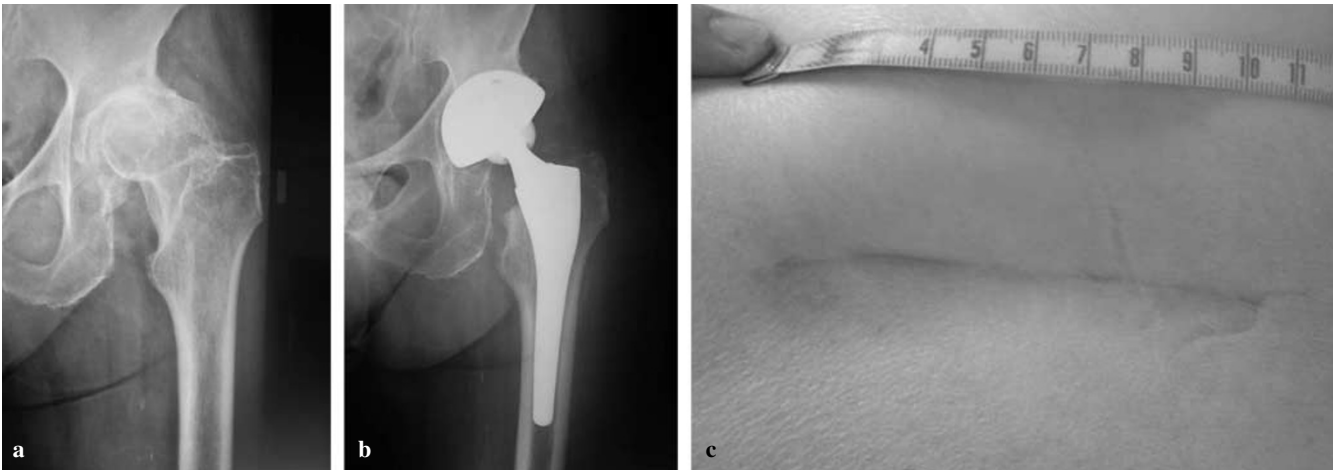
c 74 year-old female patient affected by primary osteoarthritis of the left hip. a Pre-operative X-ray. b Uncemented total hip arthroplasty performed through a minimally invasive approach. c Scar appearance at follow-up
